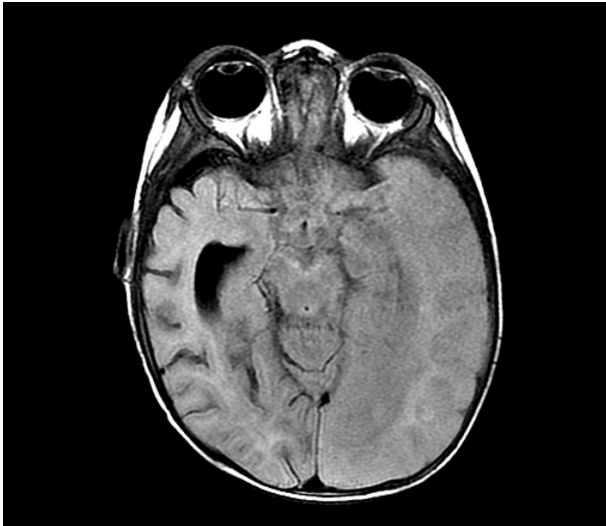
Brain magnetic resonance of the patient three days after admission. Axial FLAIR – hypersignal of the cisterns of the base, dedifferentiation between the cortex and the white matter to the left.
